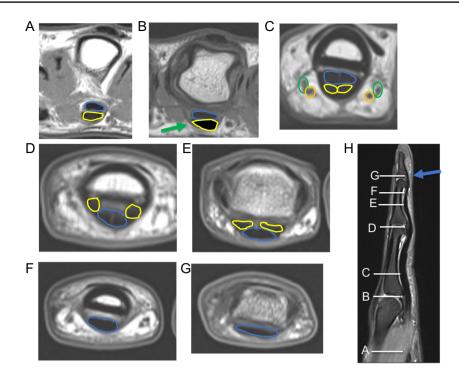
Flexor tendon anatomy on MRI. A–G Axial T1 images at the level of the palm (A), A1 pulley (green arrow, B), proximal phalanx (C), proximal interphalangeal joint (D), mid portion of middle phalanx (E), distal portion of middle phalanx (F), and base of distal phalanx (G) demonstrate anatomy of the flexor tendons. At the level of the palm and A1 pulley (A, B), the flexor digitorum superficialis (FDS) tendon (yellow) is one tendon and superficial to the flexor digitorum profundus (FDP) tendon (blue). At the level of the proximal phalanx (C), the FDS tendon bifurcates and the FDP is positioned
